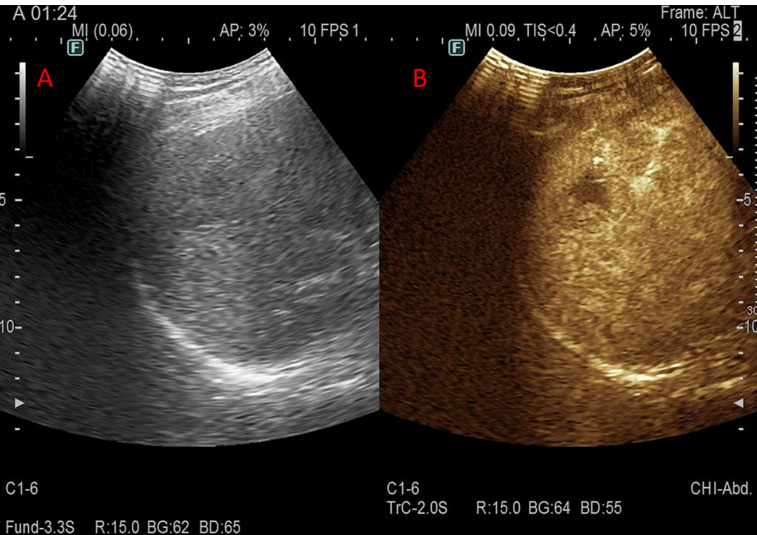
Representative CEUS images of a typical patient. The left panel displays the conventional two-dimensional ultrasound image, while the right panel shows the CEUS image following contrast agent injection. The hepatic lesion appears as a hypoechoic area on conventional ultrasound (A), and demonstrates a typical “fast-in and fast-out” enhancement pattern on CEUS (B), with low enhancement during the portal vein phase. Note: CEUS: contrast-enhanced ultrasound.
